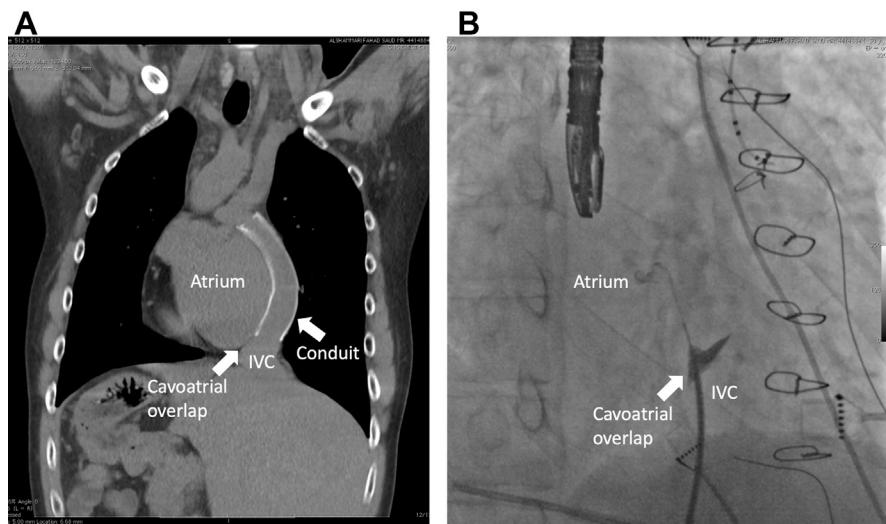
Transcaval puncture for access to the pulmonary venous atrium after extracardiac Fontan for recurrent intra-atrial reentrant tachycardia. (A) Preoperative computed tomography angiogram demonstrating a region of overlap between the inferior vena cava and the pulmonary venous atrium. (B) Fluoroscopy demonstrates contrast in the region of overlap. Contrast is injected through the needle tip into the pulmonary venous atrium before the sheath and dilator are advanced.
